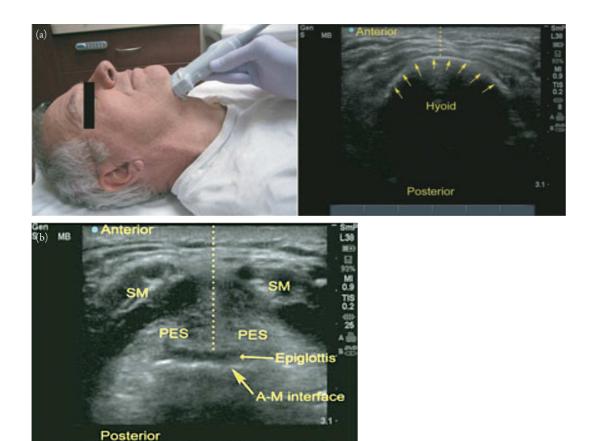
(a) Measurement of distance between skin and hyoid bone (dotted lines). Adapted from Figure 2B of Adhikari S, Zeger W, Schmier C, et al. Pilot study to determine the utility of point-of-care ultrasound in the assessment of difficult laryngoscopy. *Acad Emerg Med*. 2011;18(7):754–758. doi:10.1111/j.1553-2712.2011.01099.x. (b) Measurement at the level of thyrohyoid membrane. Measurement obtained from skin to epiglottis midway between the hyoid bone and thyroid cartilage. SM = strap muscles; PES = preepiglottic space; A-M interface = airmucosa interface. Adapted from Figure 2C of Adhikari S, Zeger W, Schmier C, et al. Pilot study to determine the utility of point-of-care ultrasound in the assessment of difficult laryngoscopy. *Acad Emerg Med*. 2011;18(7):754–758. doi:10.1111/j.1553-2712.2011.01099.x.
